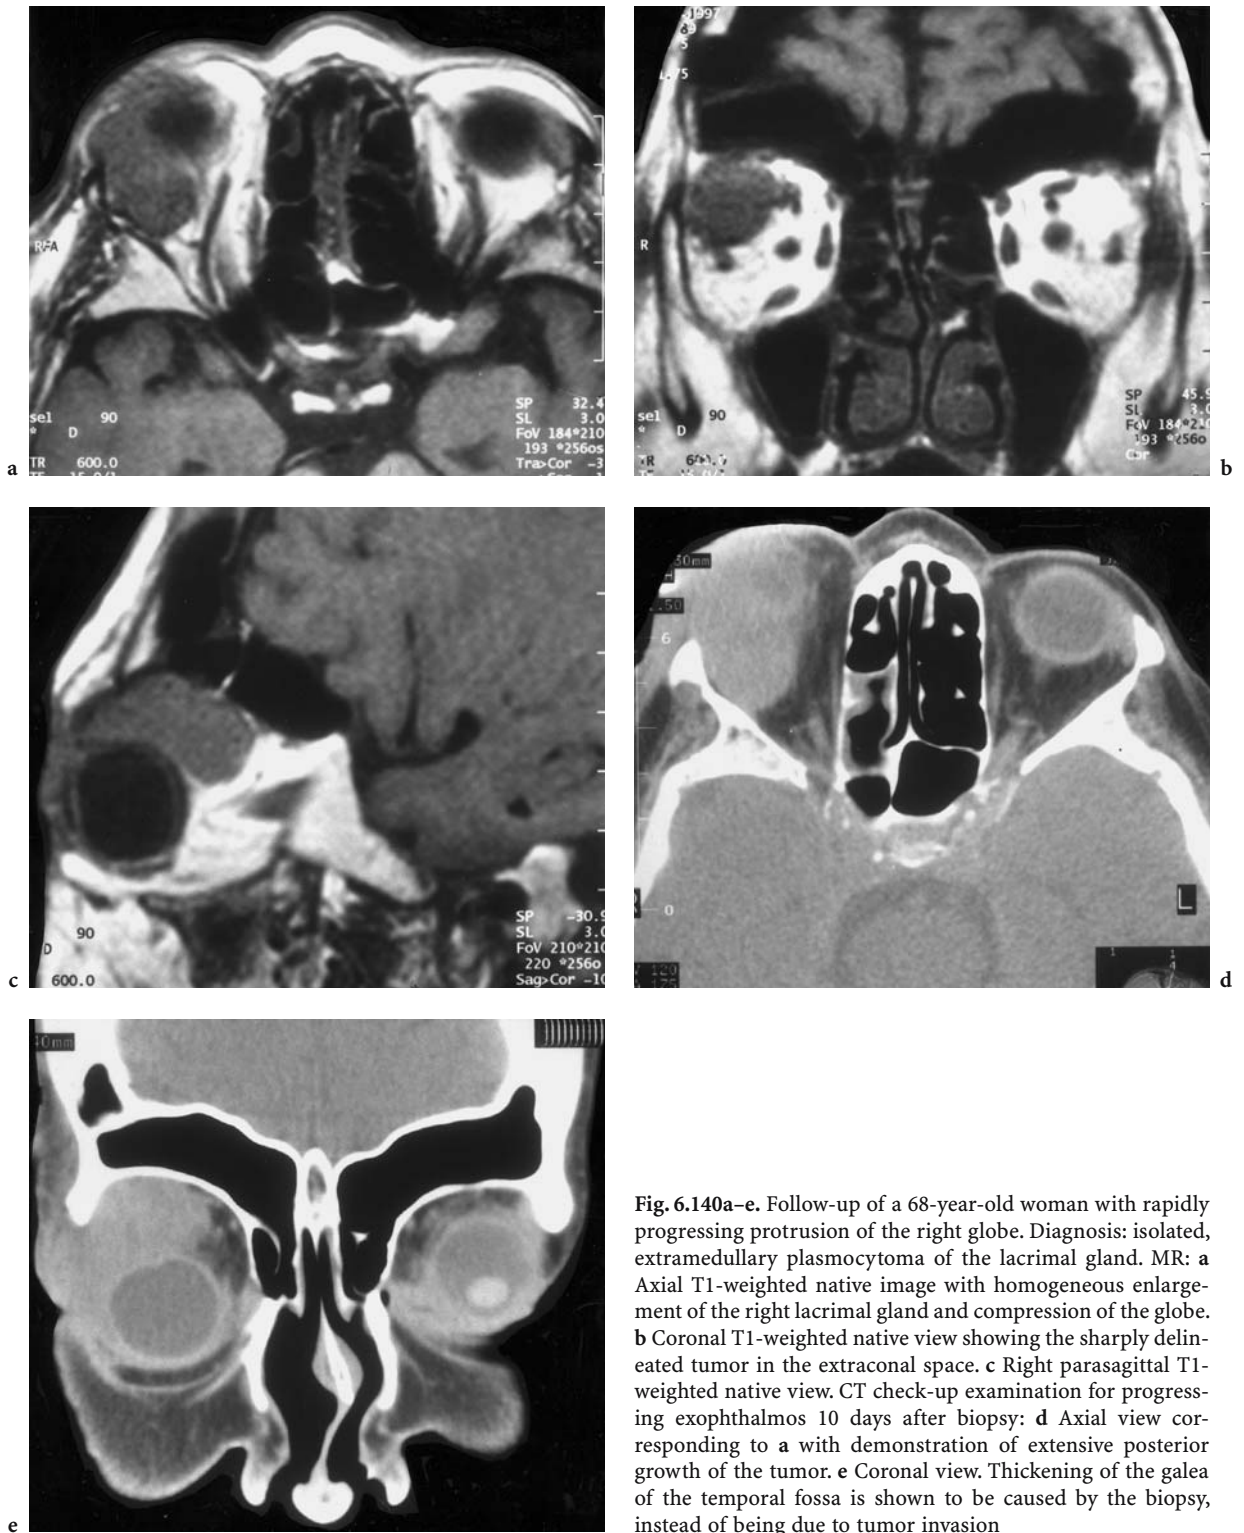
Follow-up of a 68-year-old woman with rapidly progressing protrusion of the right globe. Diagnosis: isolated, extramedullary plasmocytoma of the lacrimal gland. MR: a Axial T1-weighted native image with homogeneous enlargement of the right lacrimal gland and compression of the globe. b Coronal T1-weighted native view showing the sharply delineated tumor in the extraconal space. c Right parasagittal T1-weighted native view. CT check-up examination for progressing exophthalmos 10 days after biopsy: d Axial view corresponding to a with demonstration of extensive posterior growth of the tumor. e Coronal view. Thickening of the galea of the temporal fossa is shown to be caused by the biopsy, instead of being due to tumor invasion
